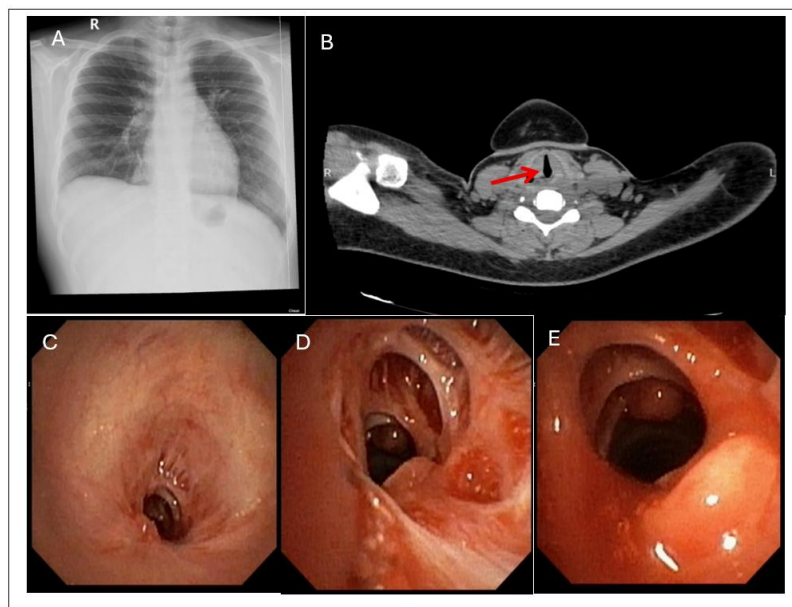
Preoperative diagnostic evaluation of Patient 2. (A) Chest radiograph; (B) Thoracic CT scan demonstrating tracheal lumen stenosis (red arrow); (C) Bronchoscopic findings showing stenosis in the proximal third of the trachea; (D) Multiple septated cicatricial tissue; (E) Tracheal nodules at the 6 and 12 o'clock positions.
